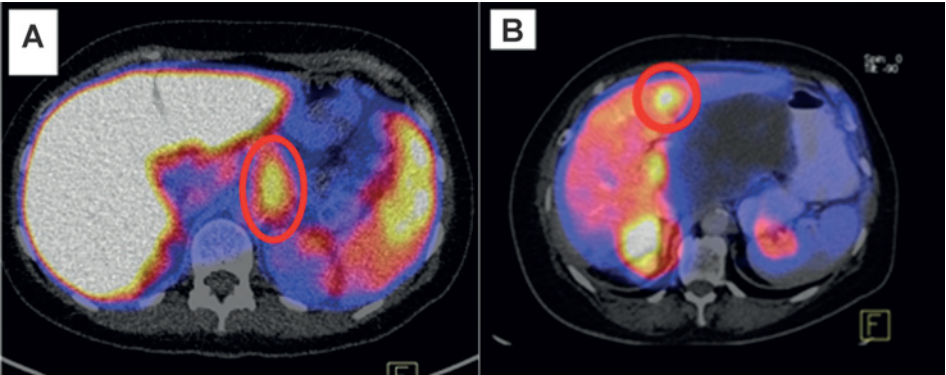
PET images 4 days postinjection from a patient with pancreatic cancer with the primary tumor ($SUV_{max} = 9.17$) encircled in red and SUV_{max} of 9.55 in the healthy liver (A); a patient with ovarian cancer with a metastasis in the ligamentum falciparum encircled with SUV_{max} of 16.6. SUV_{max} in the healthy liver is 12.9 (B).
